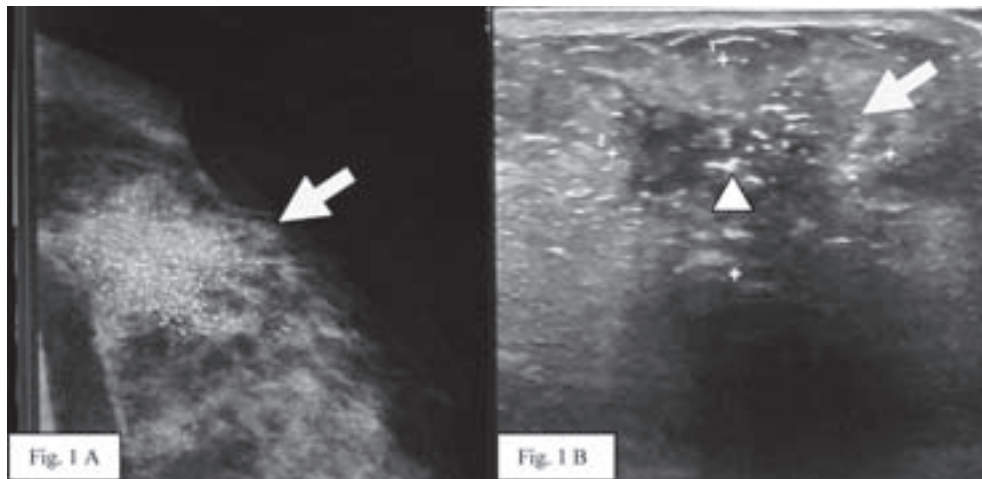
A 50 years old woman presented with a palpable left breast mass. Mammogram (Figure 1A) revealed a spiculated lesion with pleomorphic calcifications (arrow). Ultrasonogram (Figure 1B) demonstrated an irregular solid mass with indistinct border (arrow) and calcifications (arrowhead). BI-RADS 5 diagnosis was given. Pathologic diagnosis was invasive ductal carcinoma.
